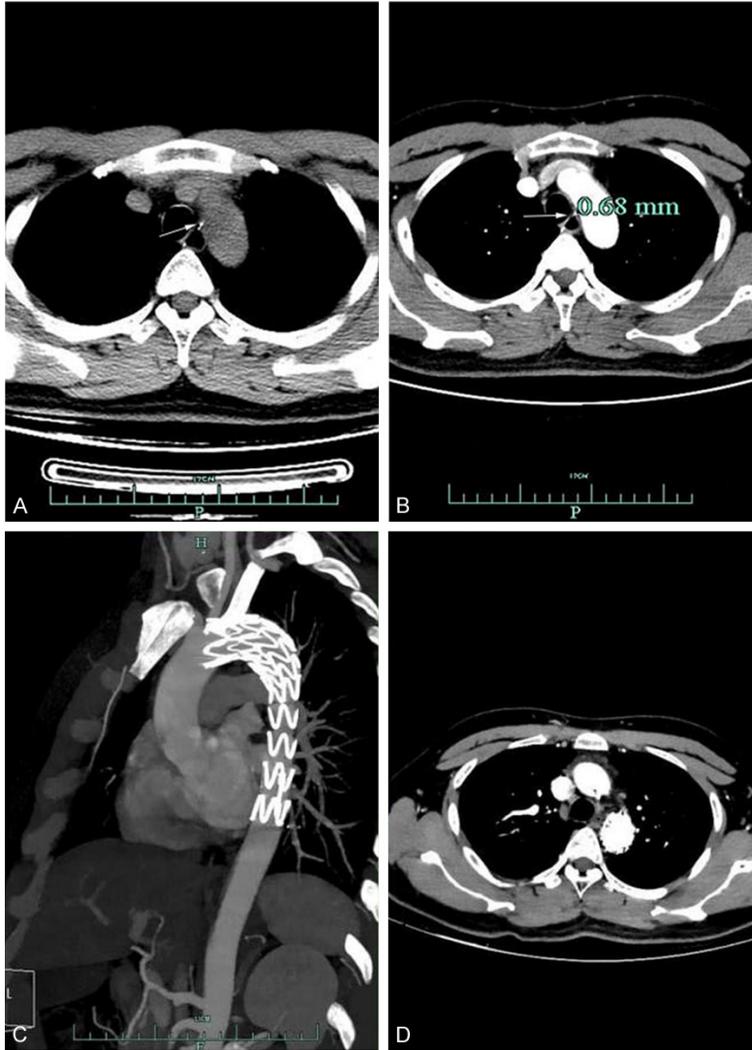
(Case 1), CT scan showed a foreign body (arrow) retained in the middle third of the esophagus about T4 level, passing through its wall, and nearly reaching the thoracic aorta (A). CTA showed the distance between the foreign body (arrow) and aortic wall was 0.68 mm, and no signs of inflammation surrounding the aorta and esophagus (B). CTA showed the stent graft had normal morphology and no signs of inflammation 22 days after the operation (C: plane of MPR, D: axial plane).
